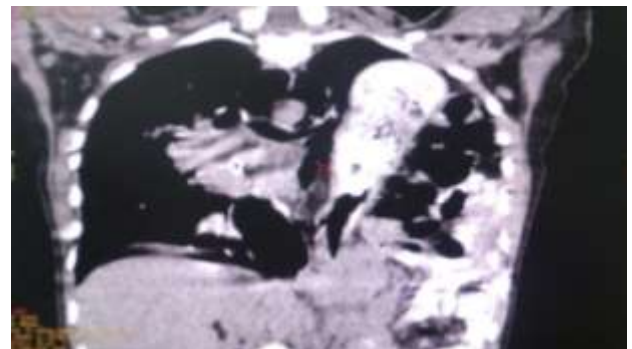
CT scan showing presence of stomach & large intestine in thorax.
